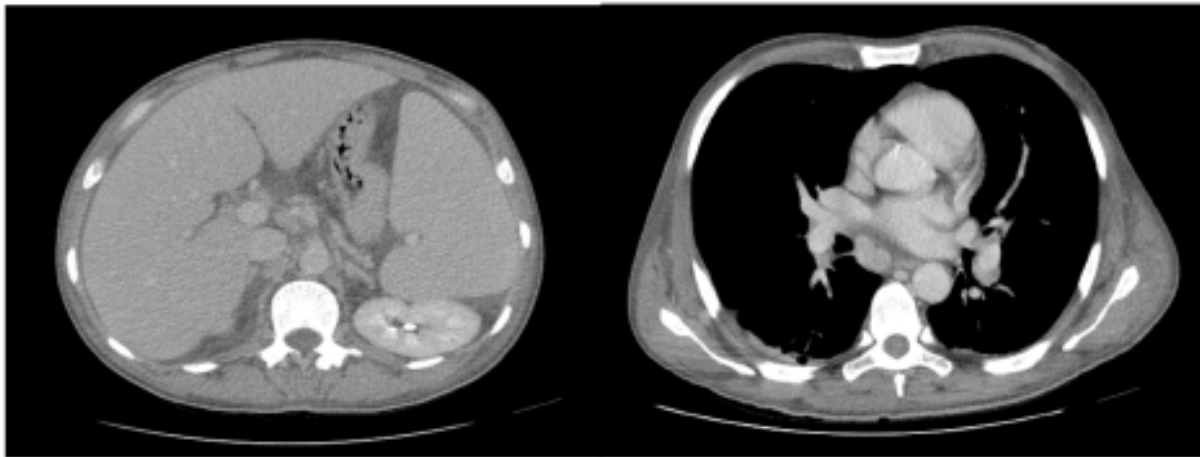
Thoracoabdominal CT with diffuse lymphadenopathy (<2 cm) and homogeneous mild hepatosplenomegaly.
